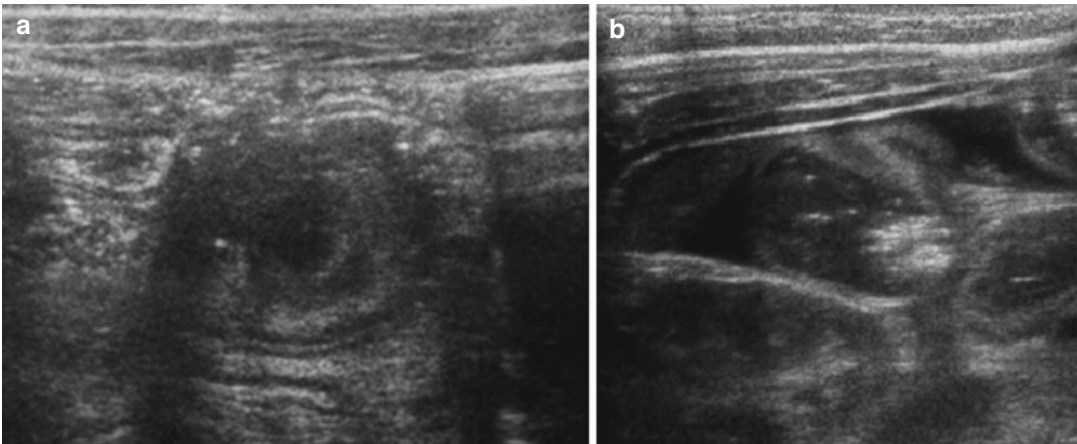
(a, b) Ultrasound axial and longitudinal scans in teenager with intestinal intussusception due to appendicitis; note the presence of free fluid between the loops
